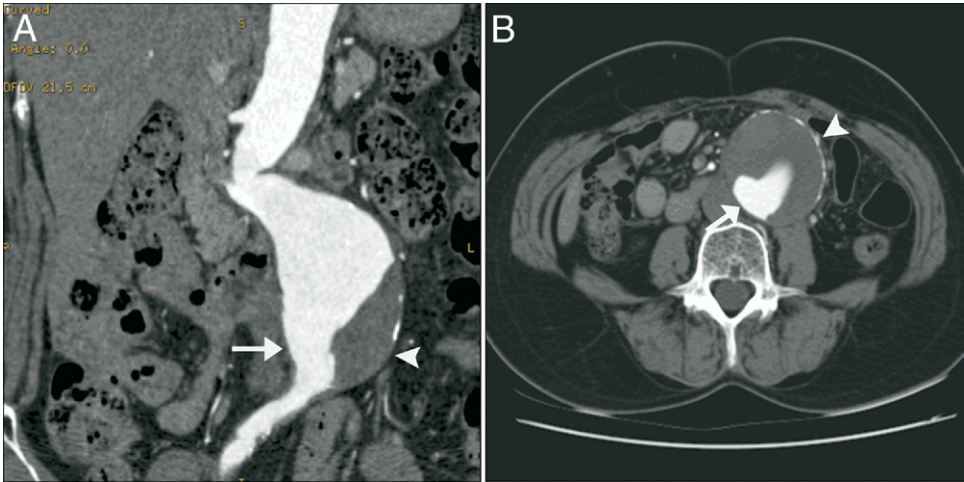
Abdominal CT Scans Demonstrating the Location of Intraluminal Thrombus at More Expanded AAA
